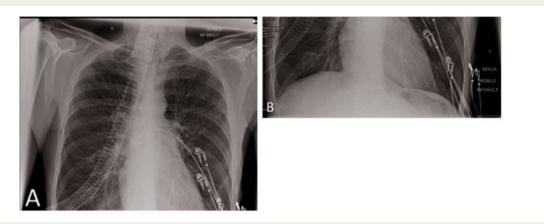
Figure I Chest radiographs on admission. (A) Hyperinflated chest with no obvious consolidation, pulmonary infiltrates, or cardiomegaly. (B) Repeat film taken at the same time as (A) with a focus on lung bases—which were clear.
